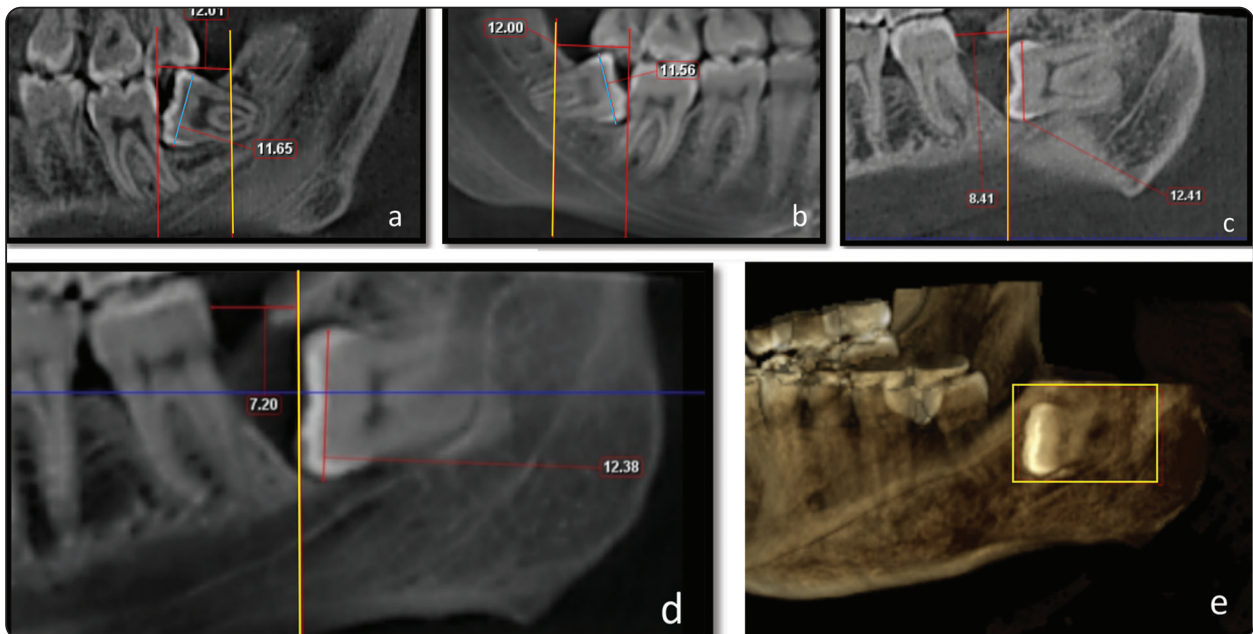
Showing the harmony between the different images of CBCT scan; a) Sagittal cut and b) Reformatted panorama of the same case impacted third molar showing the mesioangular, level A, class I pattern of impacted third molar. c) Sagittal cut, d) Reformatted panorama, e) 3D volume of the same case showing the horizontal, level C, class III pattern of impacted third molar. Note; Yellow line indicates the anterior border of ascending ramus facilitating the determination of classes.
